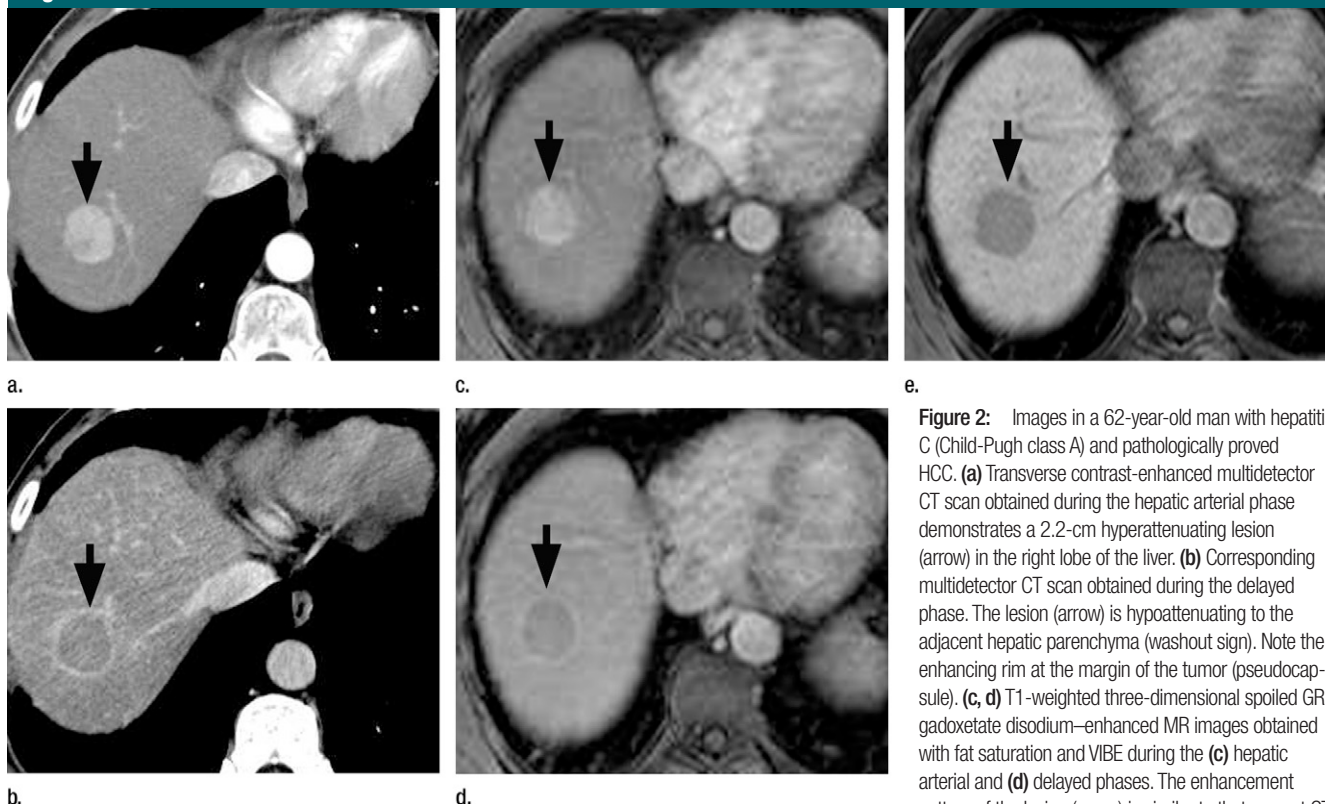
Images in a 62-year-old man with hepatitis C (Child-Pugh class A) and pathologically proved HCC. (a) Transverse contrast-enhanced multidetector CT scan obtained during the hepatic arterial phase demonstrates a 2.2-cm hyperattenuating lesion (arrow) in the right lobe of the liver. (b) Corresponding multidetector CT scan obtained during the delayed phase. The lesion (arrow) is hypoattenuating to the adjacent hepatic parenchyma (washout sign). Note the enhancing rim at the margin of the tumor (pseudocapsule). (c, d) T1-weighted three-dimensional spoiled GRE gadoxetate disodium–enhanced MR images obtained with fat saturation and VIBE during the (c) hepatic arterial and (d) delayed phases. The enhancement pattern of the lesion (arrow) is similar to that seen at CT. (e) Corresponding MR image obtained during the liver-specific hepatobiliary phase, 20 minutes after contrast medium administration. The lesion (arrow) is markedly hypointense to the highly enhanced background liver, a finding consistent with malignancy.
